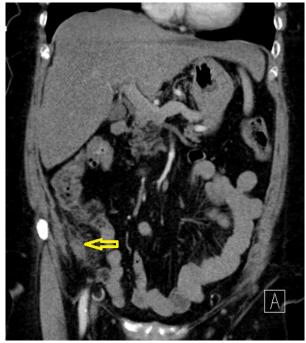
Abdominal CT showed an increase in appendix diameter and periappendiceal heterogeneity
